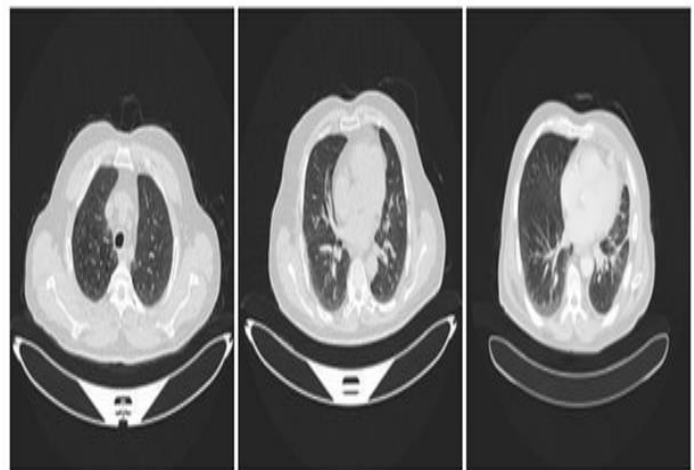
Normal, Benign and Malignant CT images.
